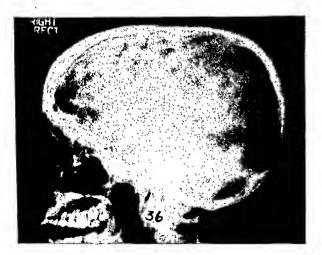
Male, aged eighteen. The thin crescentic calcification in the right occipitoparietal area near the midline was within the wall of a large arteriovenous aneurysm between the posterior cerebellar artery and the vein of Galen. Note the roentgen evidence of increased intracranial pressure.
